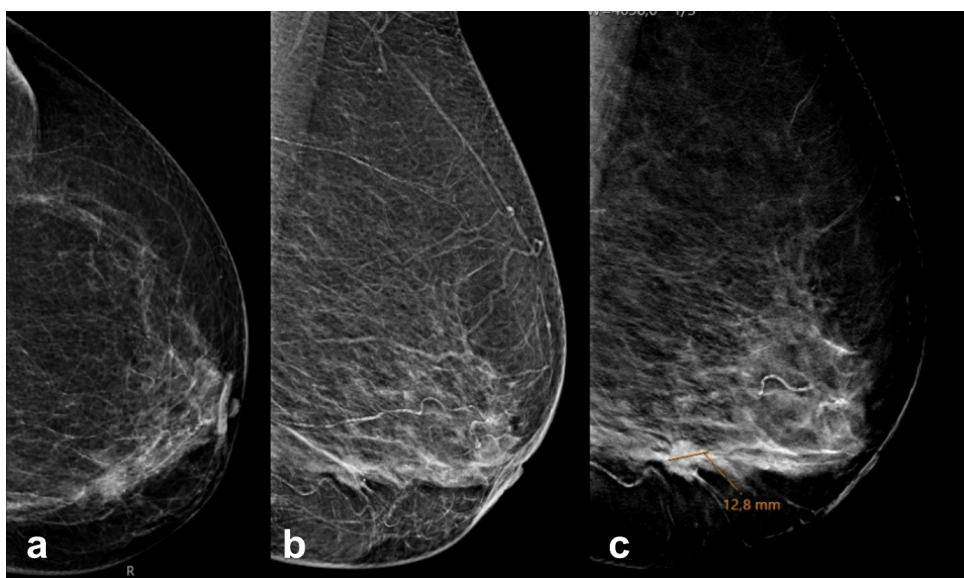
A 75-year-old woman presented with left breast hardness. A diagnostic MMG revealed linear asymmetric density accompanied by parenchymal distortion and retraction in the lower inner quadrant of the left breast, along with a millimetric nodular opacity with indistinct margins. On DBT, a 12.8 mm nodular opacity with irregular spiculated contours and highly suspicious for malignancy was clearly visible along with its contours (BI-RADS 5). (Ultrasound was also evaluated as BI-RADS 5, and the biopsy pathology report revealed invasive ductal carcinoma, grade: 3, Estrogen Receptor: 90%, Progesterone Receptor: 90%, and Ki-67 index: 10%). MMG, Mammography; DBT, Tomosynthesis; BI-RADS, Breast Imaging Reporting and Data System.
